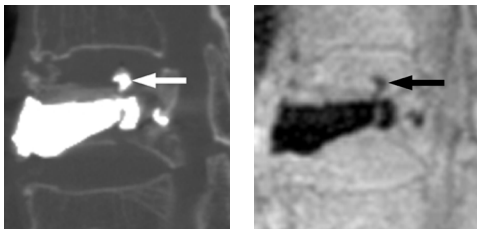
74-year-old female with compression fracture at T12. Sagittal reformatted CT (left) shows treated vertebra with an intradiskal leakage (arrow). Intradiskal leakage is well visualized on uTE (right).
